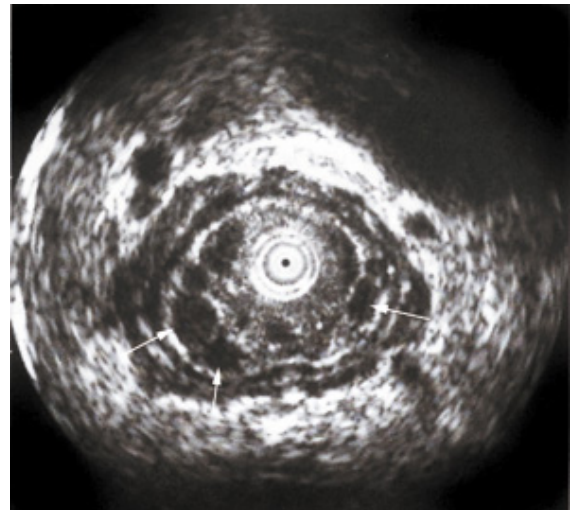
Endosonographic finding in esophageal varicosities
